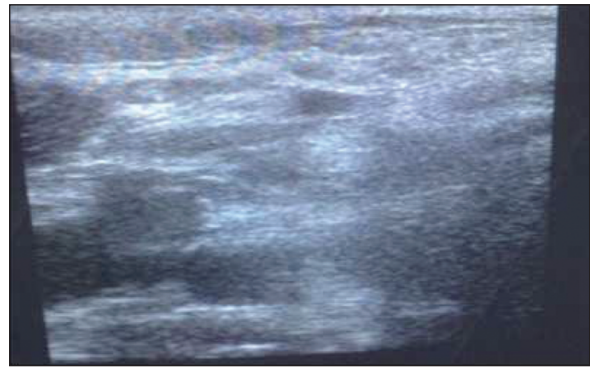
The patient's thyroid scintigraphy, bilobar thyroid agenesis (Right neck region).
